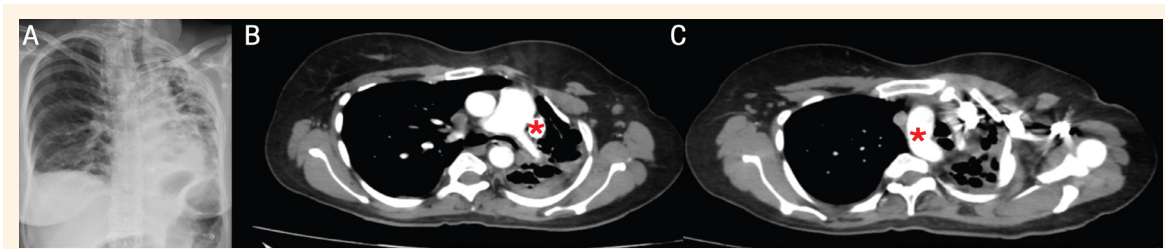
A: Chest x-ray of a 31-year-old female patient demonstrating a mediastinal shift to the left with crowding of ribs on the left with hypolucent opacity with ectatic changes on the left side. B: Computed tomography pulmonary angiogram (CTPA) showing left lung volume loss with multiple thin and thick-walled intercommunicating cystic areas and decreased caliber of the left main pulmonary artery (0.67 mm) and left superior vena cava (asterisk). C: CTPA showing right aortic arch (asterisk).
